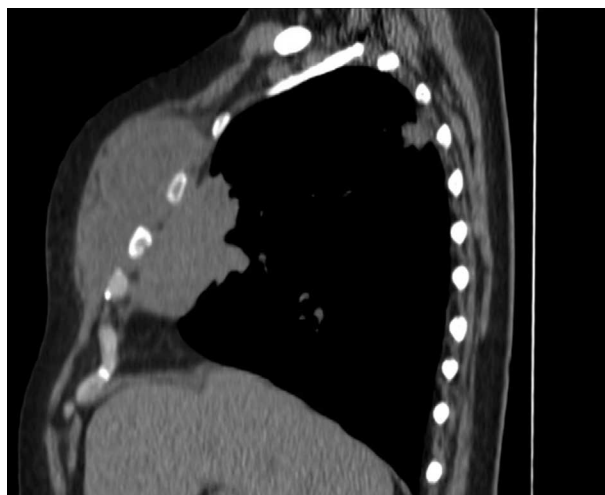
CT scan sagittal view showing rib erosion.
